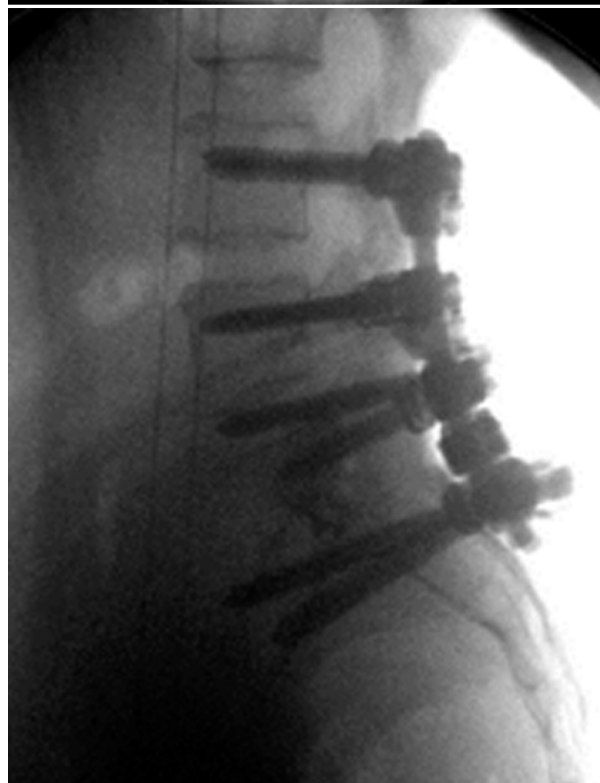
Intraoperative X-rays showing improved pelvic alignment following revision surgery with spinopelvic fixation and removal of IS screws and anterior plate.
